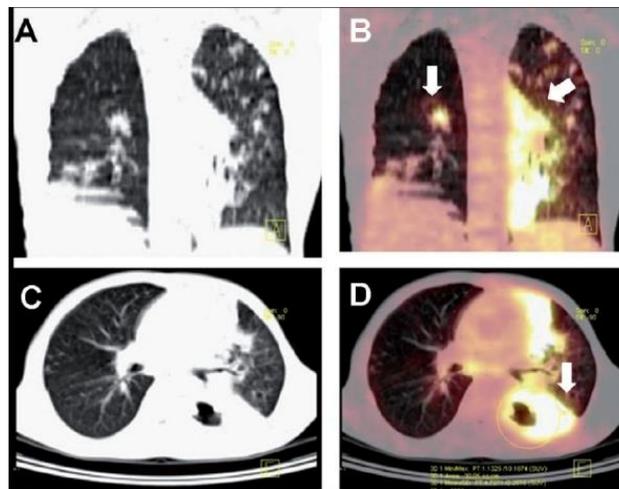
(A) coronal plane CT scan and (B) coronal plane FDG PET/CT scan of the same patient with progressive pulmonary tuberculosis, (C) transverse plane CT scan and (D) transverse plane FDG PET/CT (Harkirat et al, 2008)
